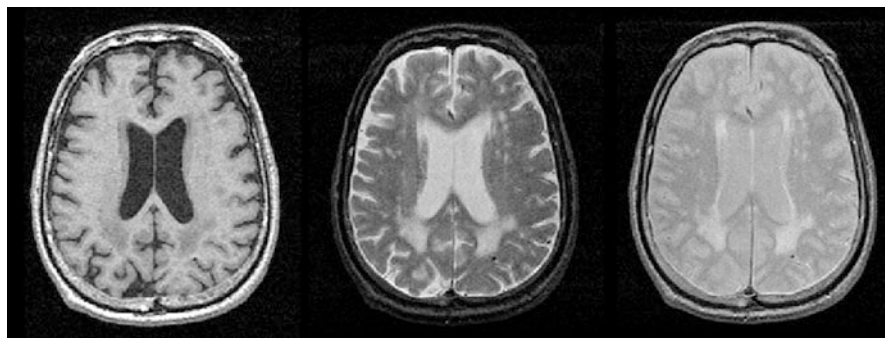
Axial views of the same brain slice, as seen on T1-weighted (*left*), T2-weighted (*middle*), and proton density-weighted (*right*) images
